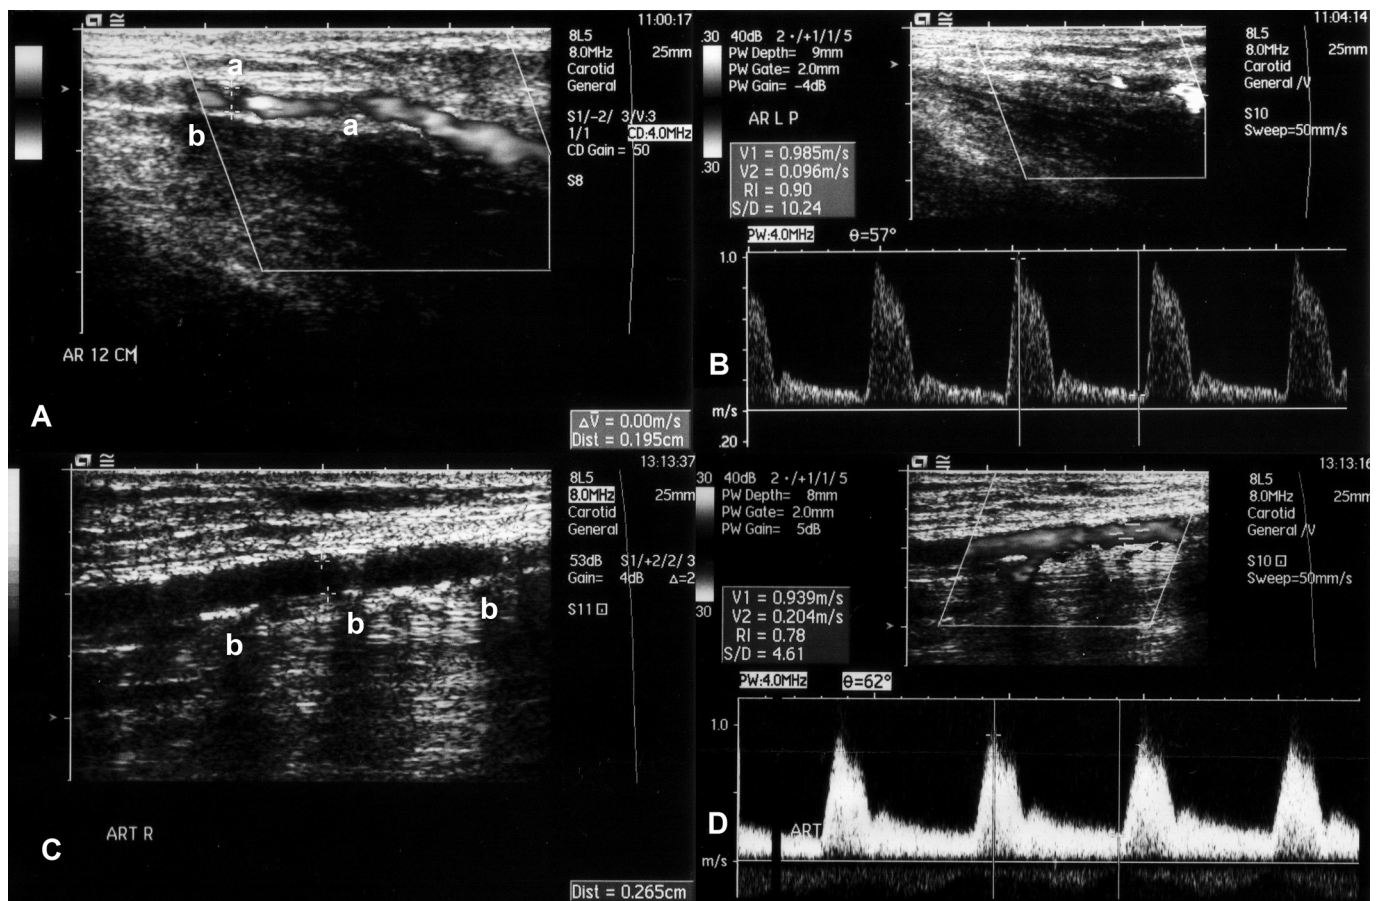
Calcified radial artery examples in two patients. Panel A: color Doppler radial artery (RA) image of patient 1; (a) note the loss of Doppler signal in areas of calcifications, the internal diameter of RA was 1.95 mm; (b) distal shadowing behind the areas of calcifications. Panel B: pulsed Doppler velocity of blood in patient 1 at hyperemic response, the resistance index (RI) of 0.9 was suboptimal but the decision to establish the fistula at this position was made due to excellent vein status (augmented cephalic vein diameter of 4.2 mm). Panel C: B-mode image of large (diameter 2.65 mm) calcified radial artery in patient 2; (b) note prominent distal shadowing behind areas of wall calcifications. Panel D: a significantly better hyperemic response with lower RI of 0.78 in patient 2.
